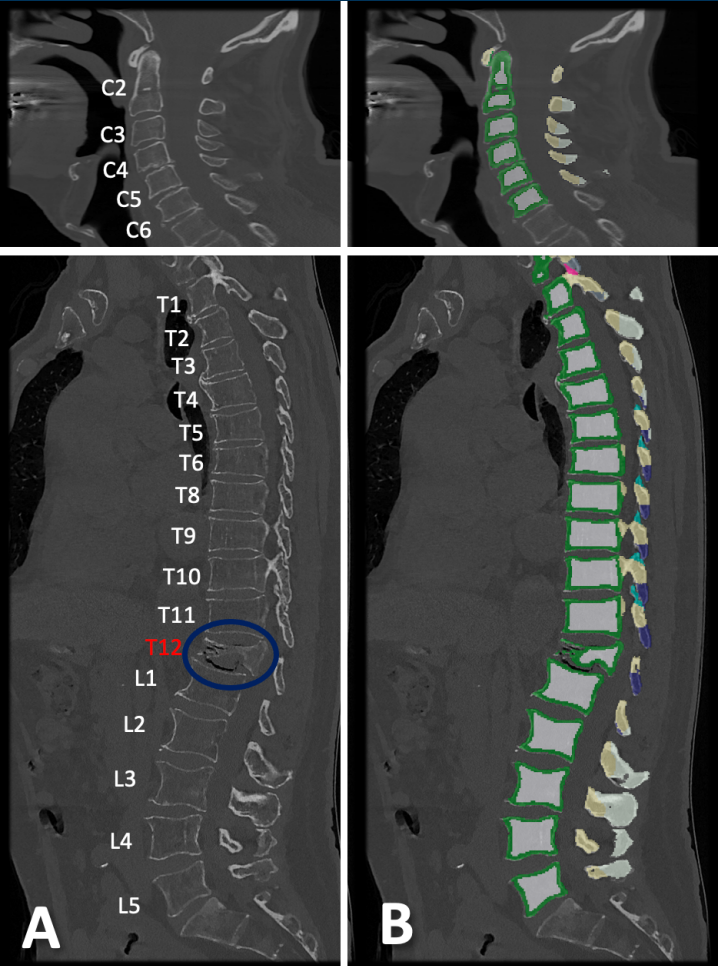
A: Non-contrast CT scan of a man with a VF at T12. B: Spine segmentations were obtained. Cervicothoracic vBMD measurements for identifying osteoporosis and prevalent VFs compared to lumbar vBMD as the reference were automatically extracted and analyzed. In this patient, all measurements correctly identified the prevalent VF.
